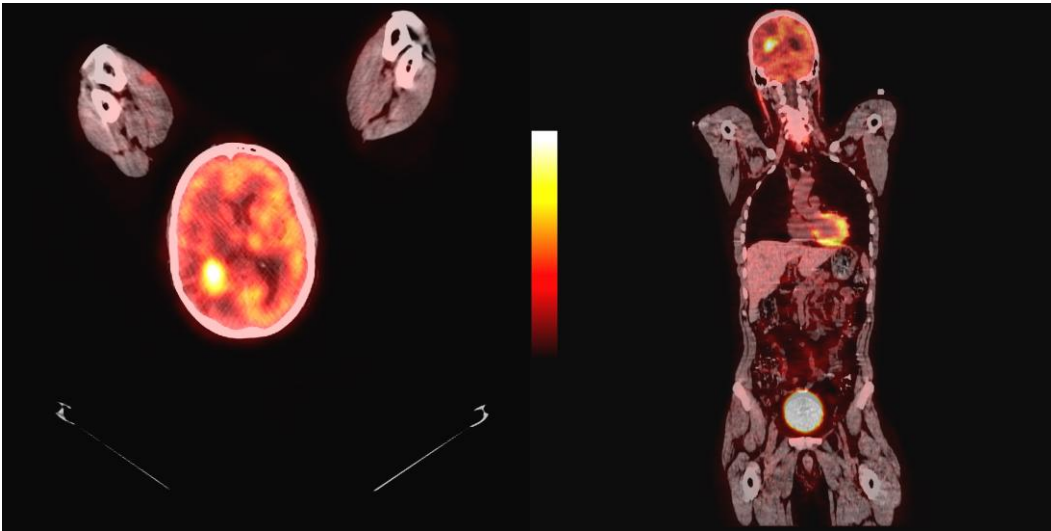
Axial and Coronal Fused PET/CT images. Decreased uptake surrounding the hypermetabolic mass corresponds to vasogenic edema.
